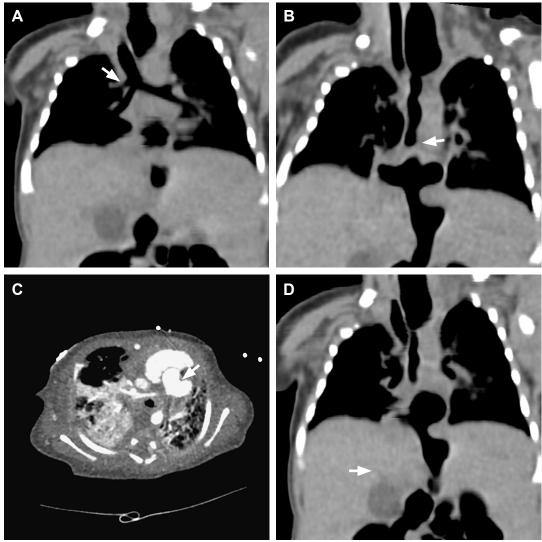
Computed tomography (CT) of a 1-day-old girl with VACTERL syndrome (A) (coronal view) shows the tracheal bronchus (arrow). (B) (coronal view) shows type D trachea-esophageal fistula with esophageal atresia (arrow). (C) (axial view) indicates an abnormal connection between the aorta and pulmonary trunk (arrow) which is diagnosed as aortopulmonary window. (D) (coronal view) reveals a round hypodense cyst located in the common bile duct which is connected to right and left hepatic duct (arrow) and the size of choledochal cyst is about 1.4 cm in diameter.
